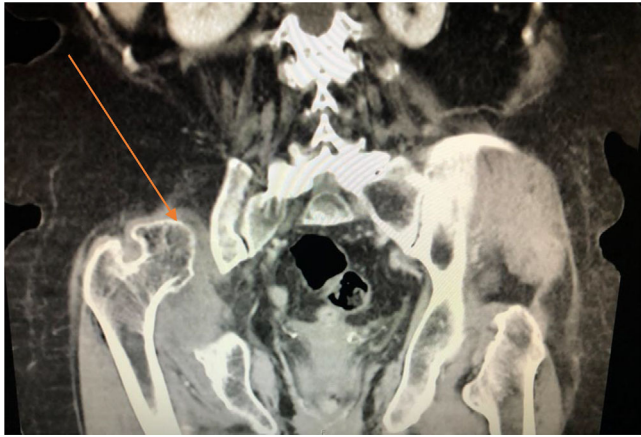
Computed tomography abdominal pelvis imaging with incidental finding of right hip dislocation (arrow). The right femoral head is visualized outside and superior to the native acetabulum
